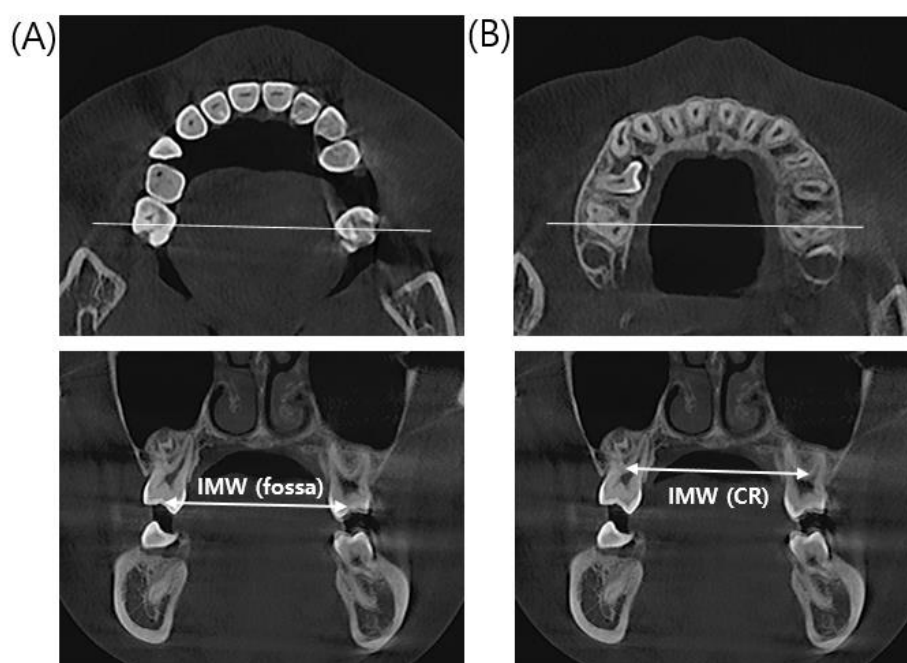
Measurements used in CBCT images (A)IMW at central fossa. (B)IMW at CR. IMW, intermolar width; CR, center of resistance
